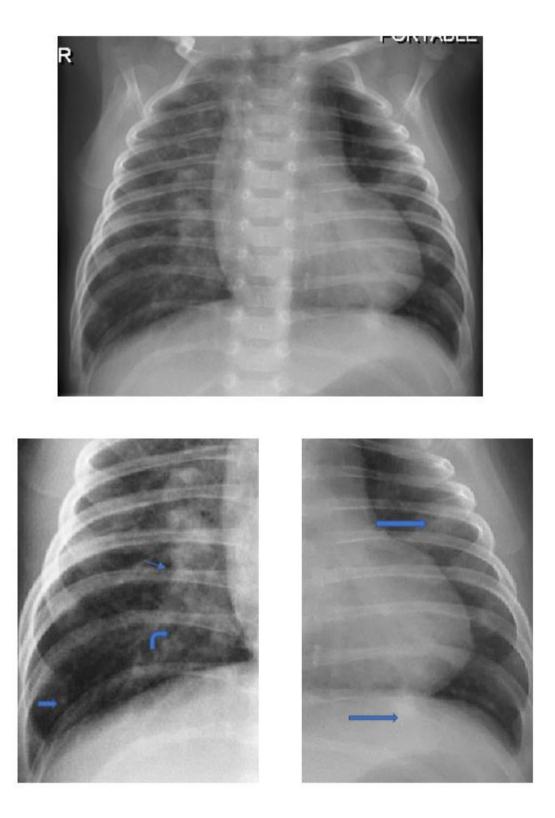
Chest radiograph with magnified views for Rt and left lower and med-zones for patient with positive PCR for Covid 19 presented with severe clinical manifestations demonstrating the beaded appearance (solid arrows), GGO (curved arrow), prominent vascular markings and peribronchial cuff (fine arrow), consolidation (long arrow), enlarged Rt hilar shadow which denote severe chest manifestation.
